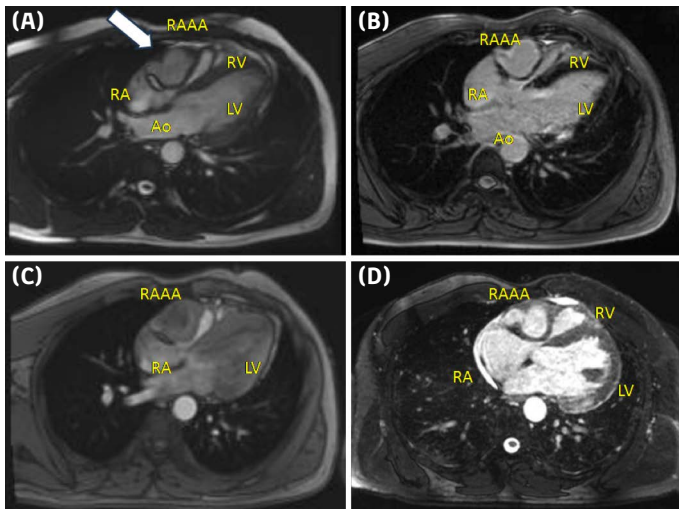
(A-D) Cardiac magnetic resonance imaging of the right atrial appendage aneurysm from various sequences (white arrow). The thrombus within the aneurysm is clearly visible.
